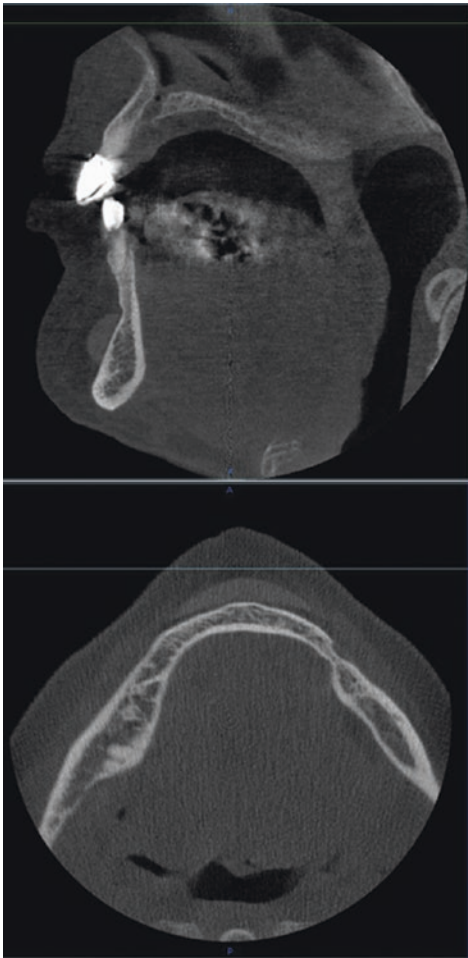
Cone beam imaging of a porous polyethylene implant (courtesy of Dr. Aditya Tadinada, University of Connecticut)
